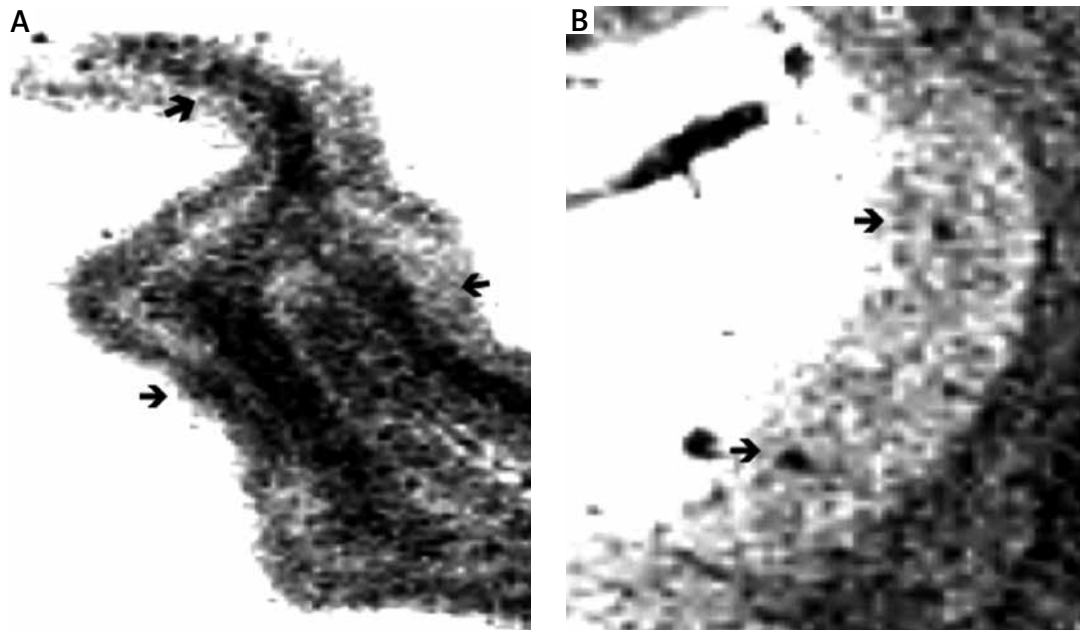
Cortical microbleeds (arrows) on T2*-weighted gradient-echo (GRE) magnetic resonance imaging of the gyrus temporalis superior (A) and in the insular cortex (B).
